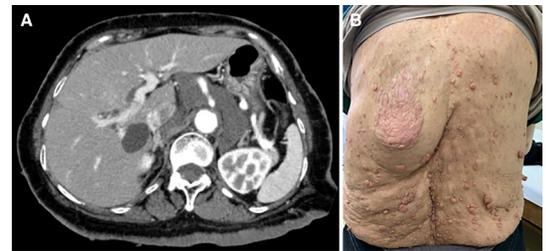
(A) Contrast-enhanced CT scan indicating a retroperitoneal mass around the abdominal aorta. (B) Numerous neurofibromas appearing on the back.
